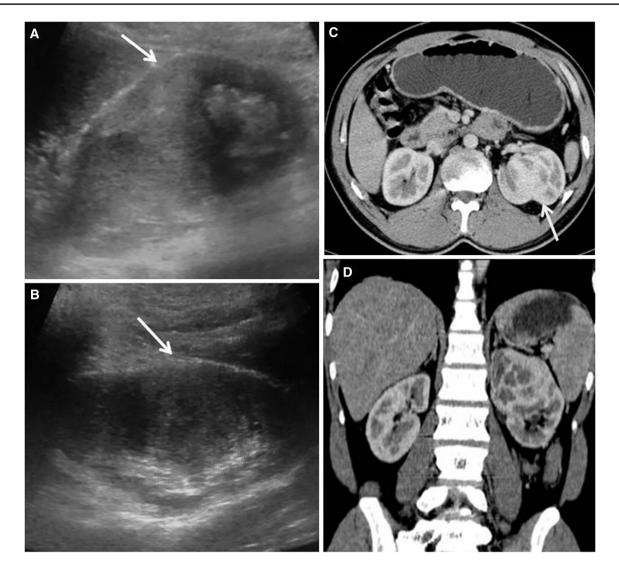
Hypertrophied column of Bertin. Sagittal ultrasound images (a, b) of the left kidney show an iso-echoic cortical mass in the mid pole (*white arrow*). Post-contrast axial and coronal CT images show
